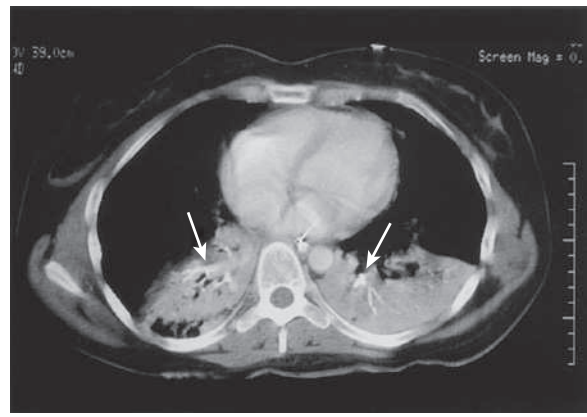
Chest CT scan showing bilateral sand bronchograms within the lower lobes (arrows) as well as significant air space opacification. (From Dunagan DP, Cox JE, Chang MC, Haponik EF: Sand aspiration with near-drowning: radiographic and bronchoscopic findings, Am J Respir Crit Care Med 156:292, 1997.)
